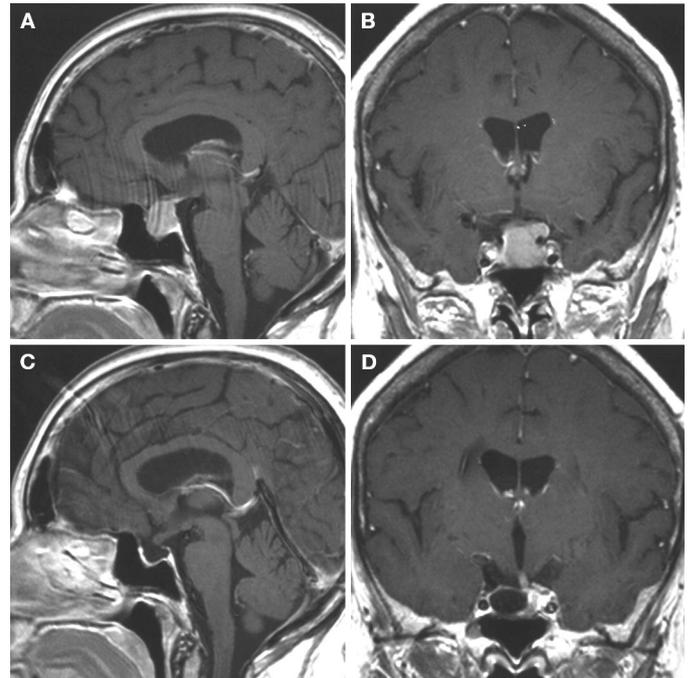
Preoperative and postoperative MRI scans of a 62-year-old woman with an intrasuprasellar pituitary adenoma. Note that the tumor has grown through the diaphragma sellae, making a transsphenoidal exposure impossible (A and B). With endoscope-assisted microsurgical techniques via a contralateral supraorbital craniotomy, the adenoma was completely removed (C and D).
